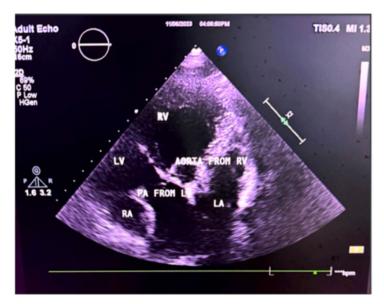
Echocardiographic cross-section highlighting atrioventricular and ventriculoarterial discordance.
